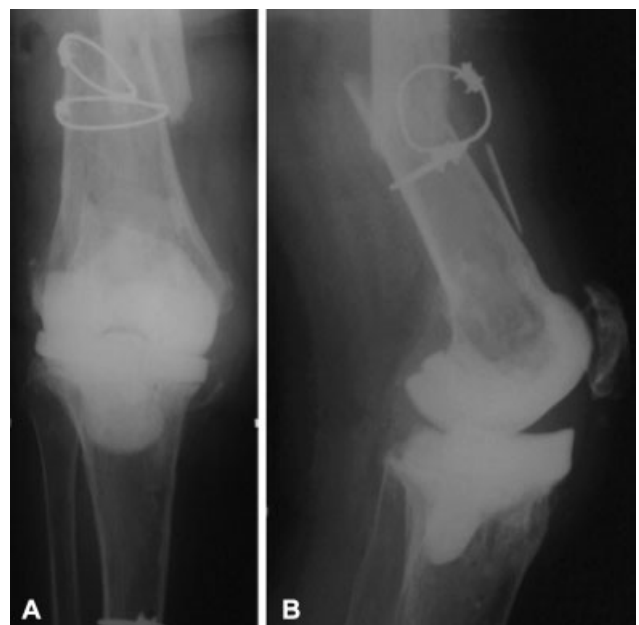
Anteroposterior (A) and lateral (B) X-rays show a fracture at third distal of femur above the spacer.
